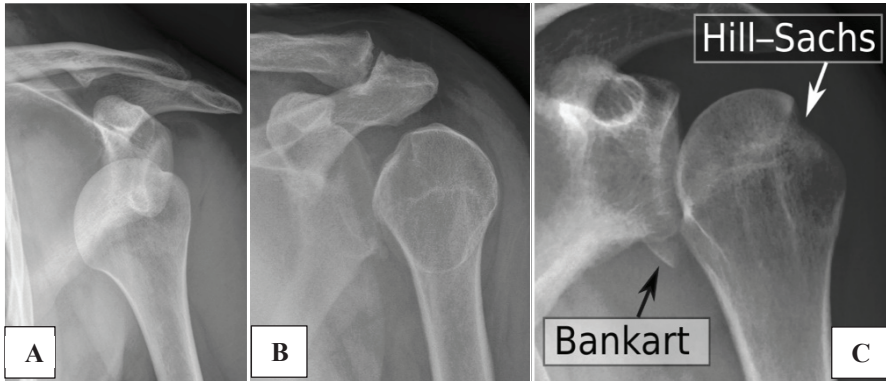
Demonstrates appearances on AP shoulder radiographs. A) Anterior shoulder dislocation; B) Posterior shoulder dislocation; C) Hill-Sachs and Bankart lesions post reduction of a different shoulder (Wikipedia, 2019).
